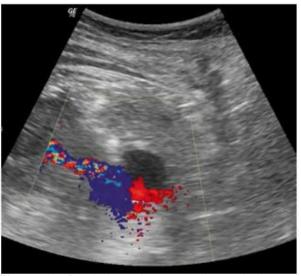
Renal hemorrhage – ultrasound image of pseudoaneurysm in retroperitoneum to aneurysms
